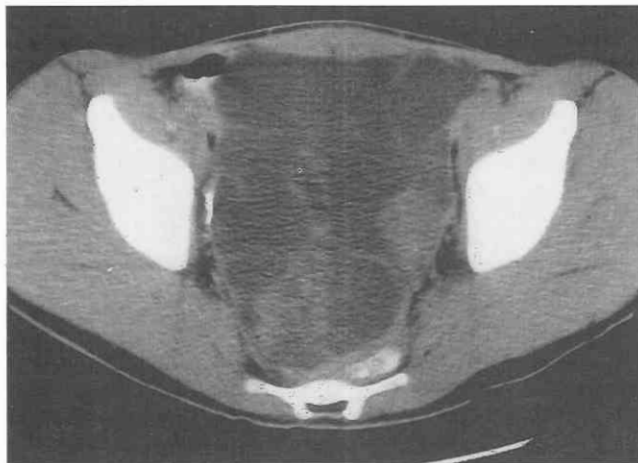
Peritoneal cystic mesothelioma. CT scan through the pelvis shows a large, multiseptated, cystic mass. At surgery, a cystic peritoneal mesothelioma was noted.
